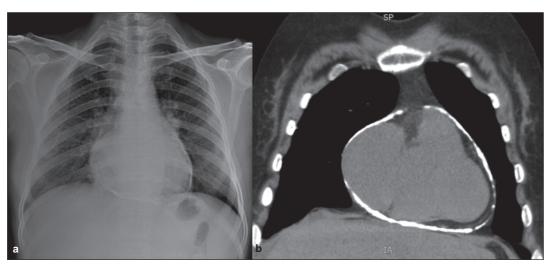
(a) Chest X-ray in posteroanterior projection showing a radiopaque shadow around the heart. Mild pulmonary venous congestion is evident. Distended superior vena cava is also seen, (b) Plain CT scan shows the heart almost fully encased in a calcific shell.
